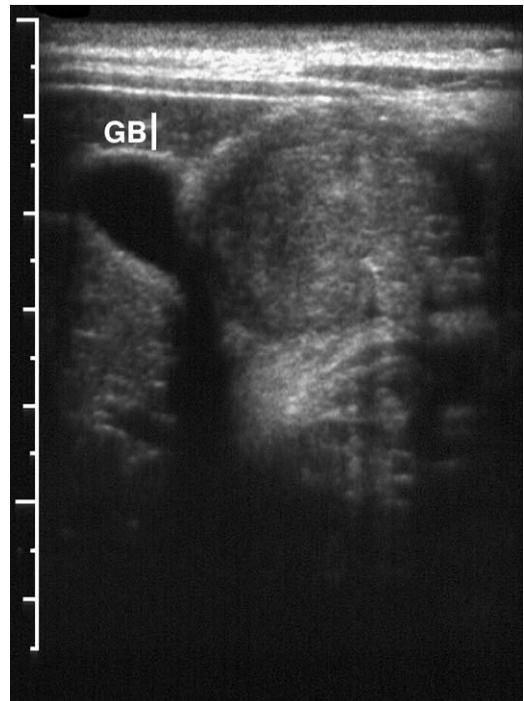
Intestinal intussusception. Transverse sonographic image demonstrates a soft tissue mass in the right upper quadrant adjacent to the gallbladder (GB).
